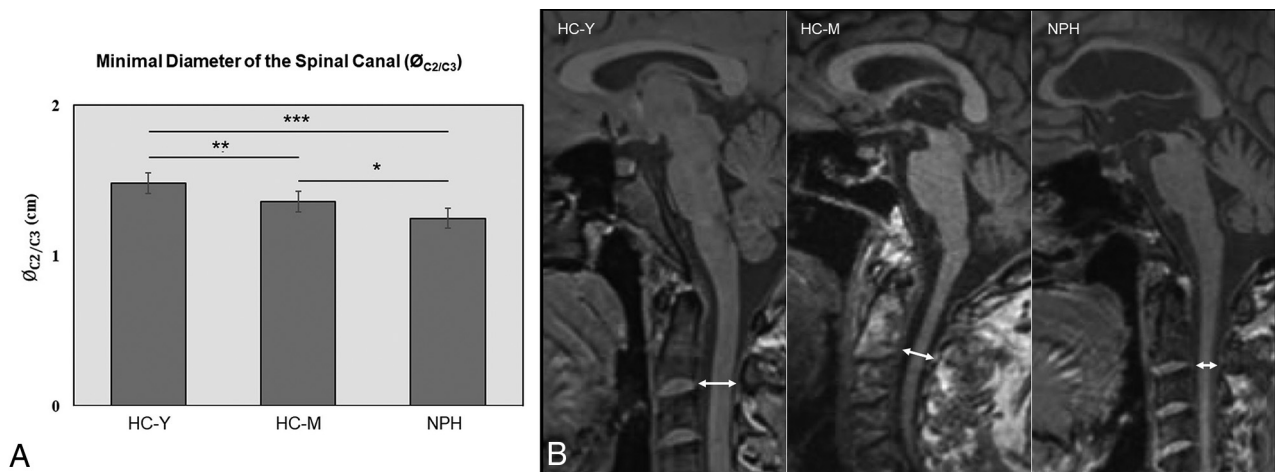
Minimal diameter of the spinal canal ($\varnothing_{C2/C3}$). A, Minimal diameter of the spinal canal ($\varnothing_{C2/C3}$) in centimeters. B, Representative MR images (midsagittal T1-weighted image) to measure the minimal diameter of the spinal canal at the level of the intervertebral space between the second and third upper cervical vertebrae (double-sided arrow). The left panel shows an image of an HC-Y, the middle panel shows an HC-M, and the right panel shows an image of a patient with NPH. The asterisk indicates $P < .05$; double asterisks, $P < .01$; triple asterisks, $P < .001$.
